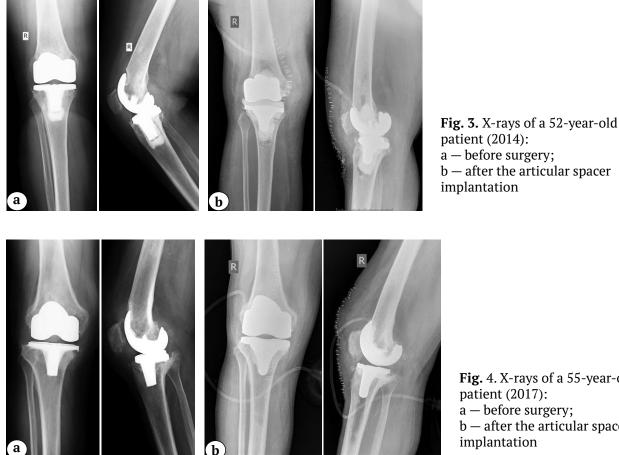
X-rays of a 55-year-old b — after the articular spacer
